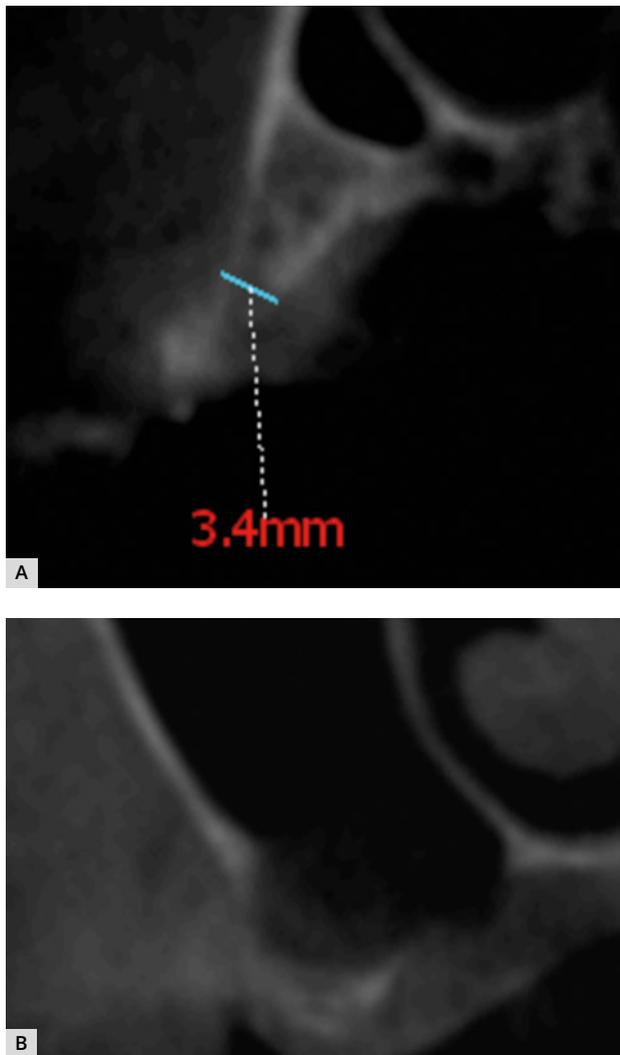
Preoperative CBCT images: A) Preoperative CBCT showing sagittal view of the narrow ridge at #11 site; B) Preoperative CBCT showing sagittal view of sinus wall thickness over #12-#14 sites.
